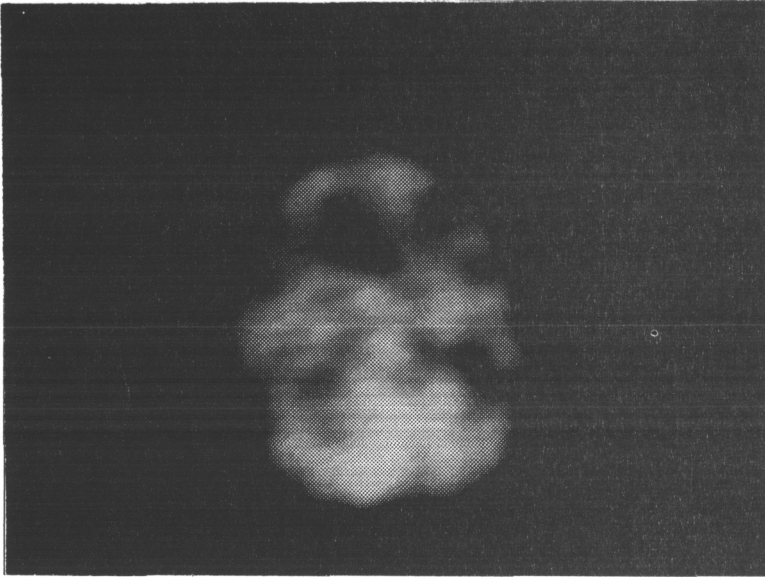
This SPECT demonstrates large right parietal areas of hypoperfusion, diffuse small multifocal regions of cerebral hypoperfusion, and periventricular scalloping.*
